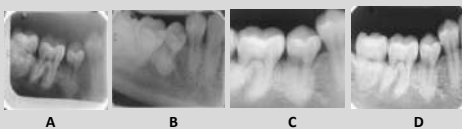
(A, B, C, D): Periapical radiography assesment of the second right lower premolar. A-initial radiography; B-after 1 year; C-after 2 years; D-after 4 years.
